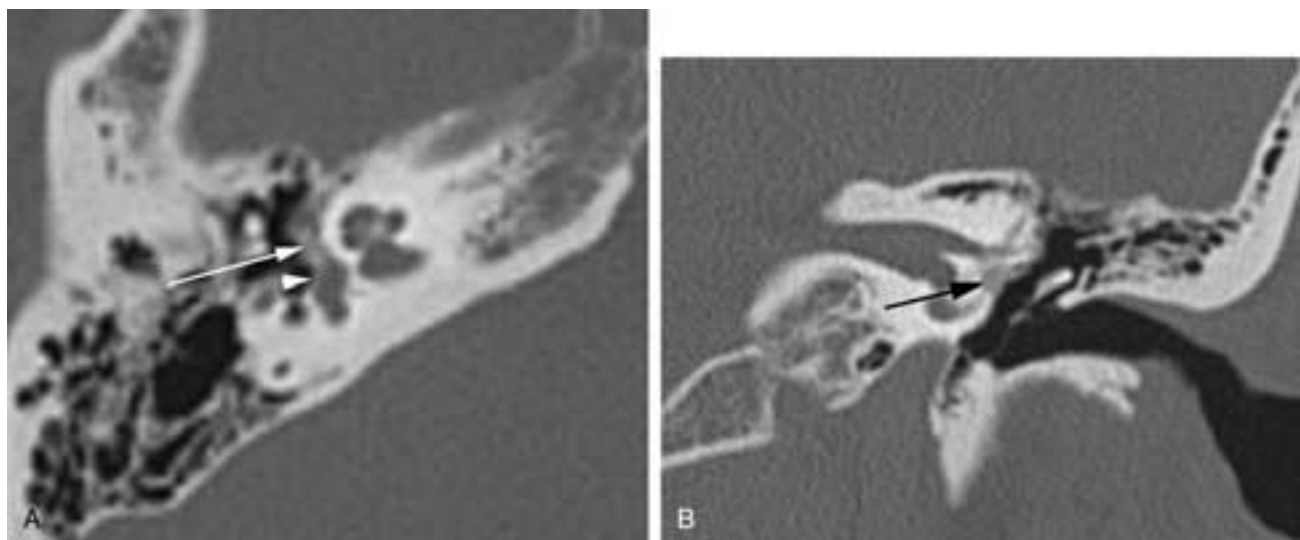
Otosclerosis impinging on the footplate of the stapes. A, Axial CT image shows the intermediate density bone (*arrow*) just anterior to the oval window impinging on the footplate of the stapes (*arrowhead*). B, The focus of demineralization (*arrow*) just anterior to the oval window. Note that the focus of demineralization abuts the medial aspect of the facial nerve canal.
